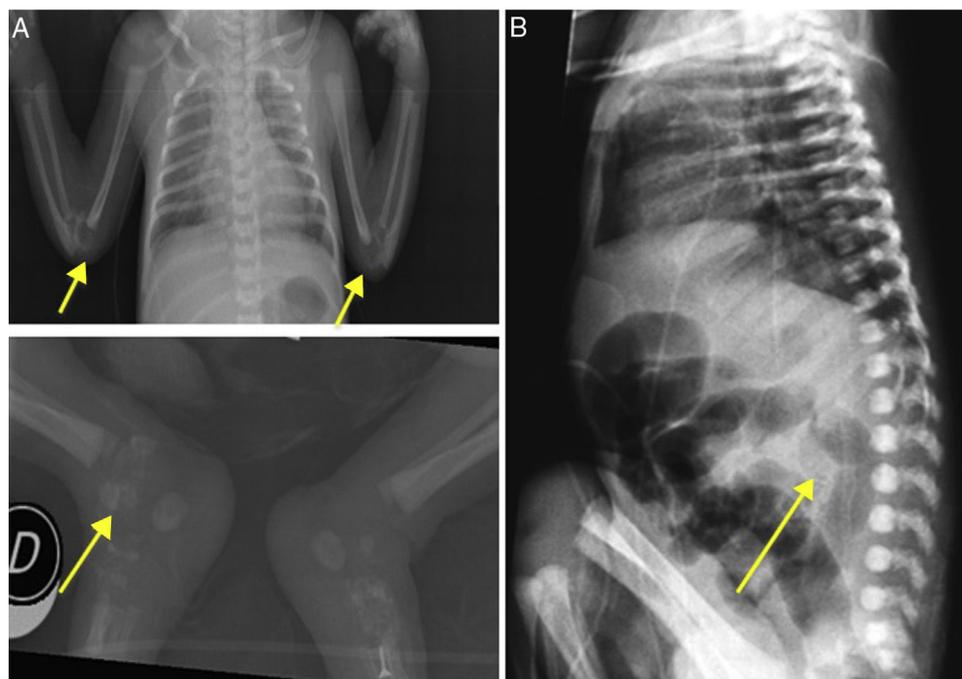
A, limb X-ray (calcifications indicated by arrows). B, abdominal X-ray: calcification of the descending aorta.
